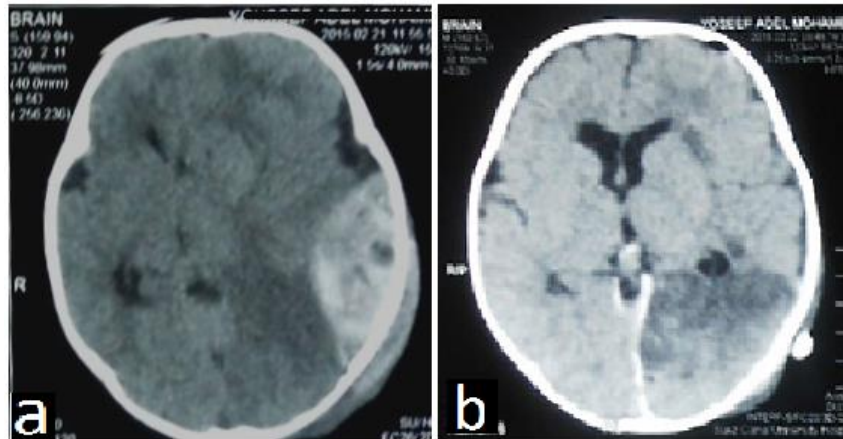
Preoperative (a) and postoperative (b) CT images of a 7 years old girl with huge left temporoparietal EDH following a traffic accident
